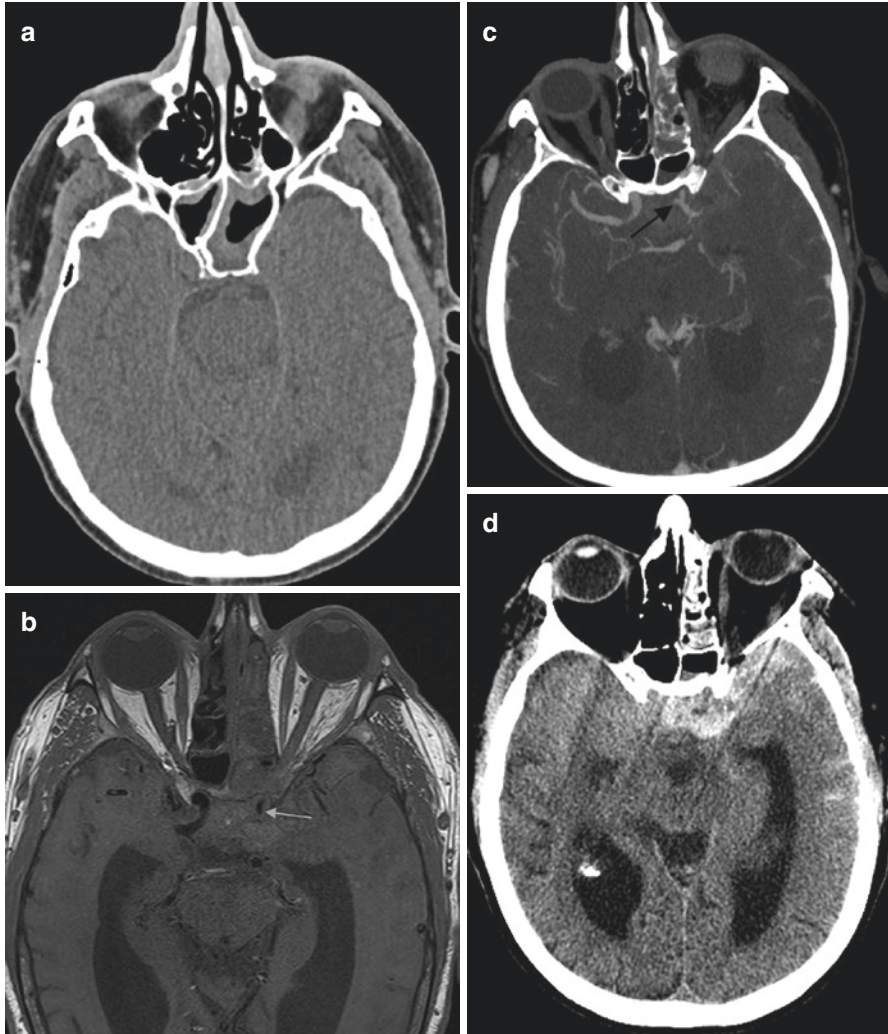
Middle-aged male on dialysis presents with nonspecific inflammatory mucosal thickening of the left sphenoid sinus (a) on noncontrast CT of the face, which progressed rapidly in size on subsequent imaging (images not available). Patient develops left third and fourth cranial neuropathies and noncontrast brain MR (b) due to renal failure, which shows marked narrowing of the left intracranial internal carotid relative to the right (*arrow*) with biopsy proven fungal sinusitis at the orbital apex (not shown). Emergent intracranial CTA was done (c) and showed a new clinoid left internal carotid artery aneurysm and narrowing (*arrow*) when compared to prior CTA (not shown). Patient became confused, and noncontrast head CT (d) shows subarachnoid hemorrhage from rupture of the infectious clinoid internal carotid artery aneurysm
